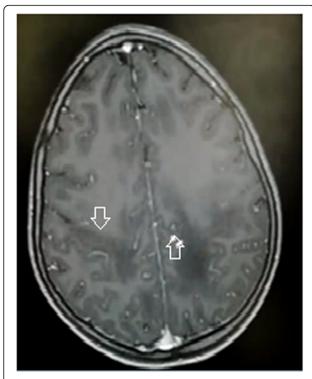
MRI brain demonstrates ADEM patchy enhancement pattern, axial post-contrast T1WI showing patchy enhancement of bilateral parietal subcortical lesions (arrows)
